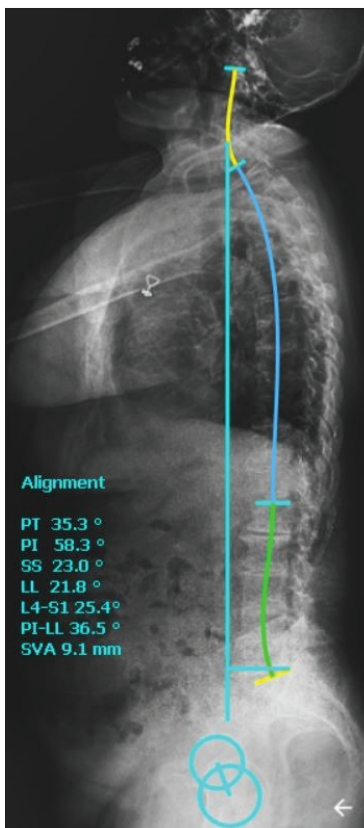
Preoperative lateral X-ray of the patient who underwent long-level fusion.
